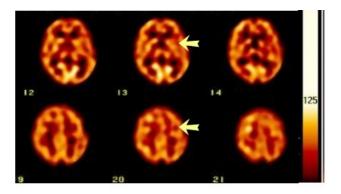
The SPECT brain perfusion images of our patient. Note the relatively decreased activity in the left putamen and frontoparietal area indicated by the open arrowhead.
